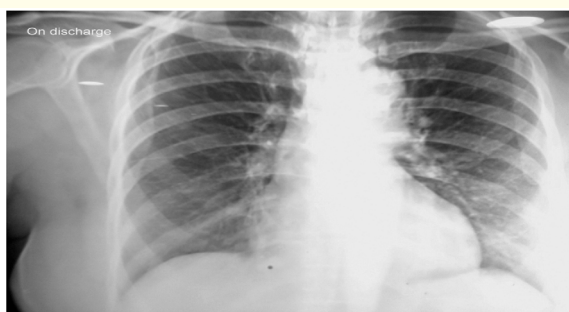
Post procedure x-ray showing opened right lower lobe.
